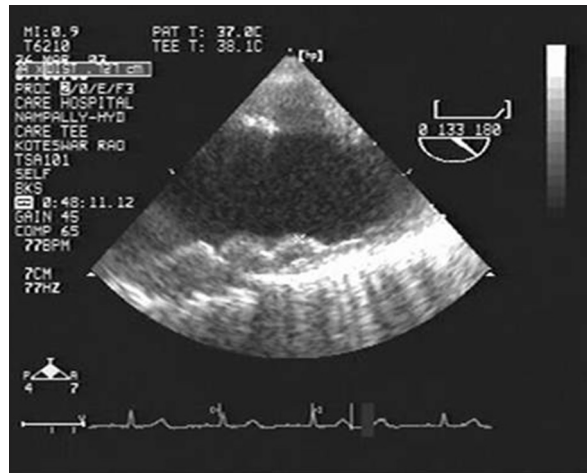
Grade IV atheroma on transoesophageal echocardiography
